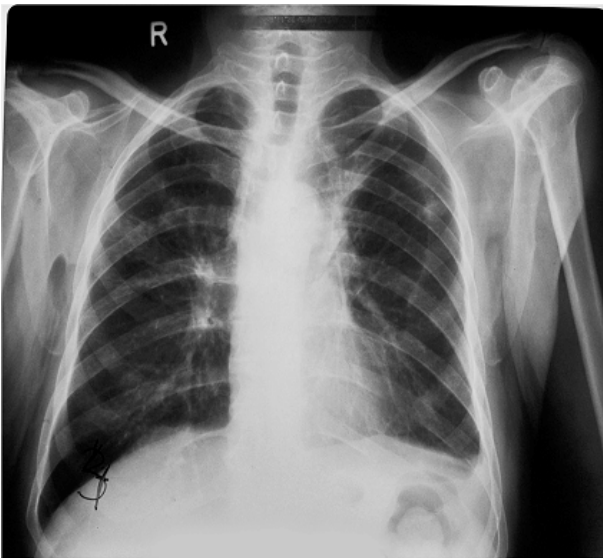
Chest radiography: complete withdrawal of the pleural effusion.
